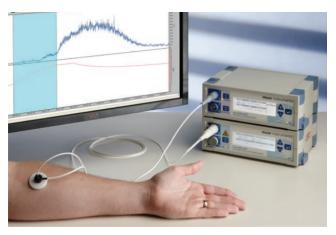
A Laser Doppler FLowmetry probe is placed on the forearm to measure the tissue blood flow⁶².
